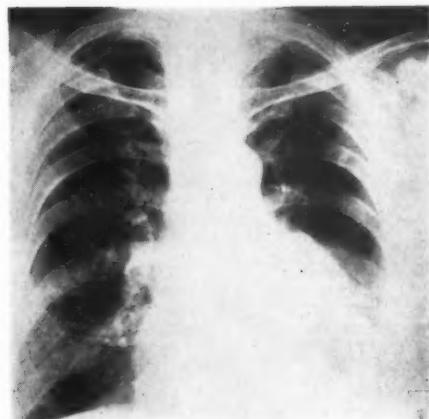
X-ray shows re-expansion of lingula, but left lower lobe remaining collapsed following removal of left intra-bronchial lipoma.
